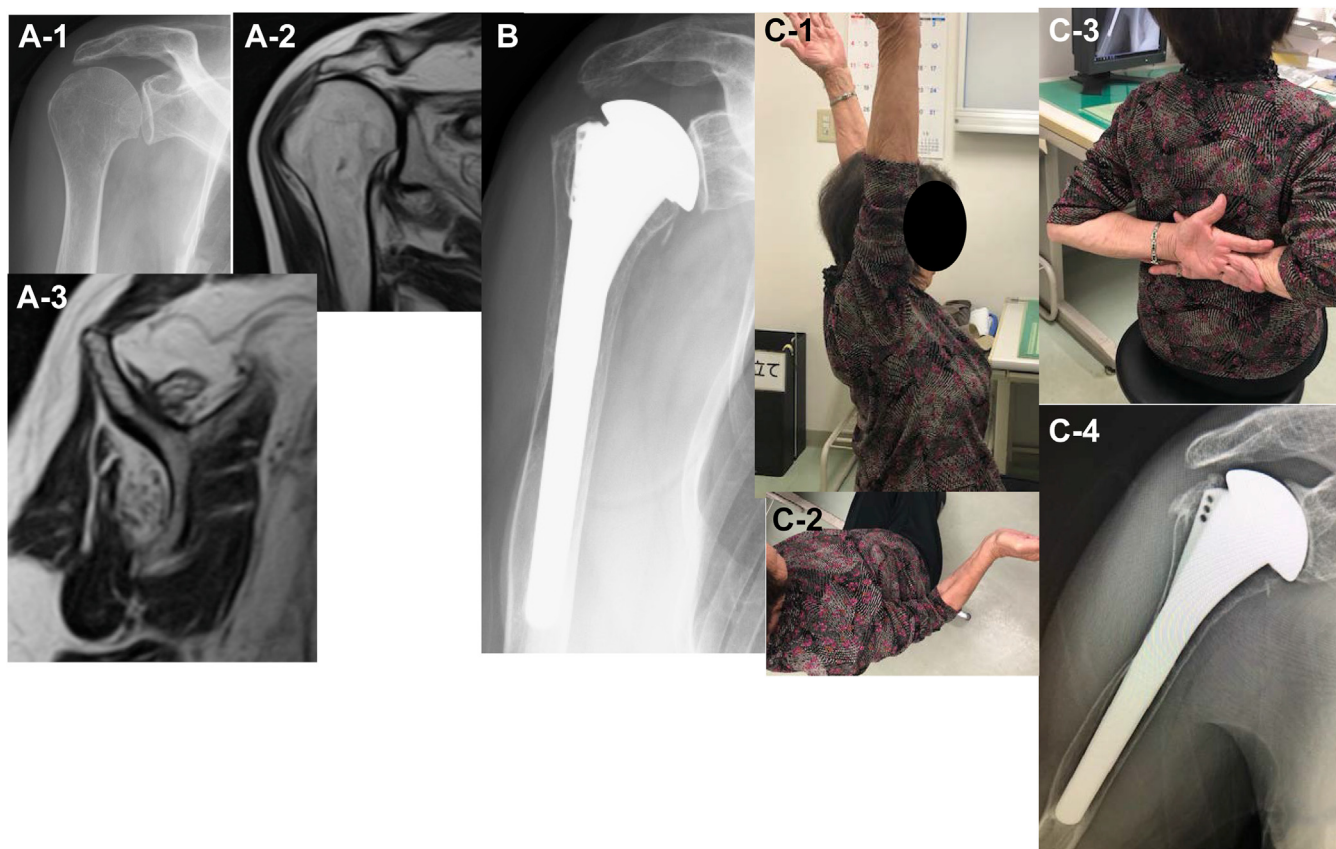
A female patient with CTA who was 76 years old at the time of surgery. HHR with a smaller head with partial subscapularis transfer and latissimus dorsi and teres major muscle transfer was performed. (A1-3): preoperative X-ray and magnetic resonance imaging image. (B): X-ray image 1.5 years postoperatively. (C1-4): Thirteen years postoperative ROM and X-ray image. The JOA score was 94 points and UCLA score was 34 points. The X-ray revealed grade 3C glenoid wear and grade 4 bone resorption. CTA, cuff-tear arthropathy; HHR, hemiarthroplasty; ROM, range of motion; JOA, Japanese Orthopaedics Association score; UCLA, University of California, Los Angeles shoulder score.
